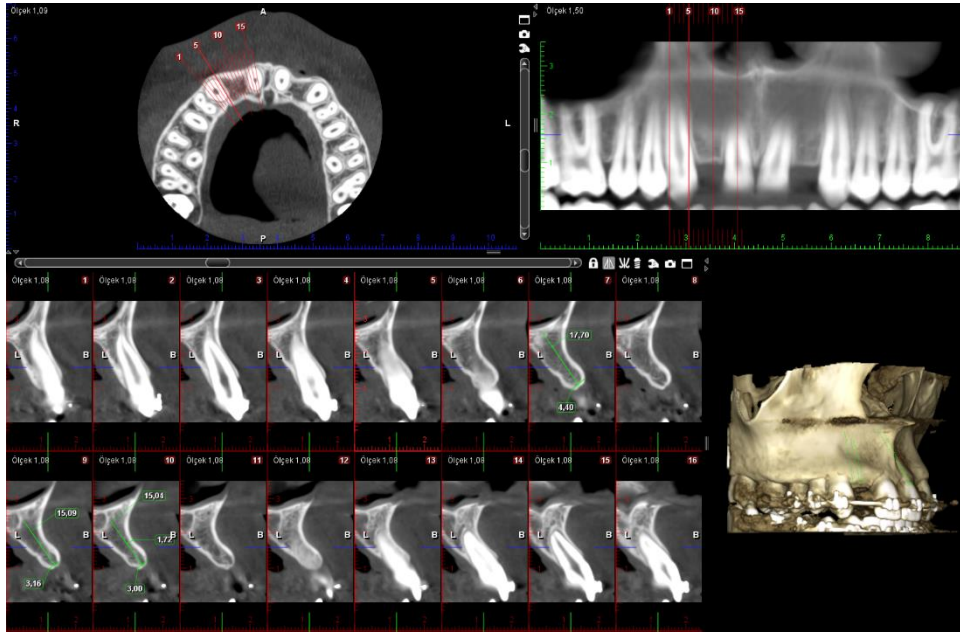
CBCT slices showing the maxillary right lateral incisor area
